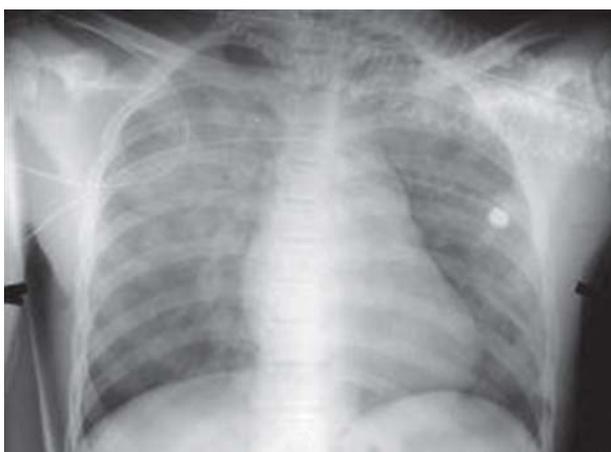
X-ray showing bilateral bronchovascular markings
